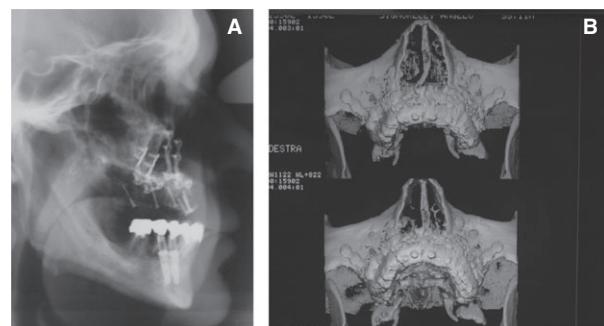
(A, B) Postoperative radiographs clearly show the bone gain obtained and the correction of the horizontal retrusion of the maxilla, recreating a class 1 intermaxillary relationship.
